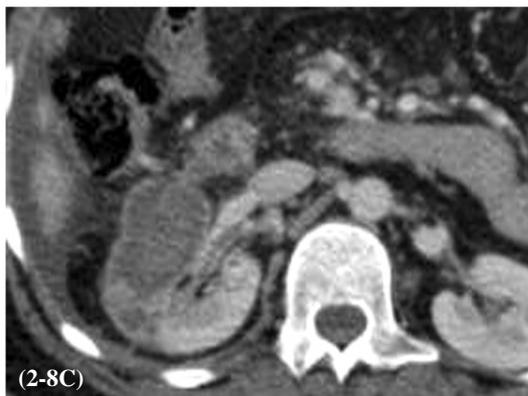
A, B, C: (Non contrast, Arterial and nephrographic phases) axial CT images, D: Excretory phase coronal CT image, are obtained 1 month after 3rd RF ablation session show reduced size of ablated right renal mid zone mass lesion, stranding perinephric fat and no residual enhancing tumor tissues.
